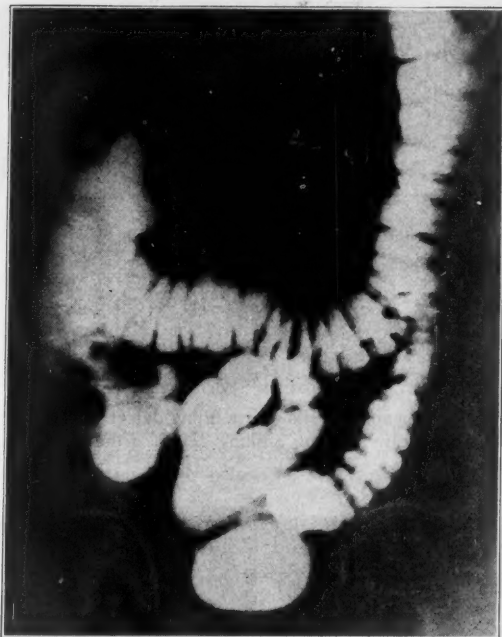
Roentgenogram showing a large filling defect in the first portion of the ascending colon due to carcinoma.
